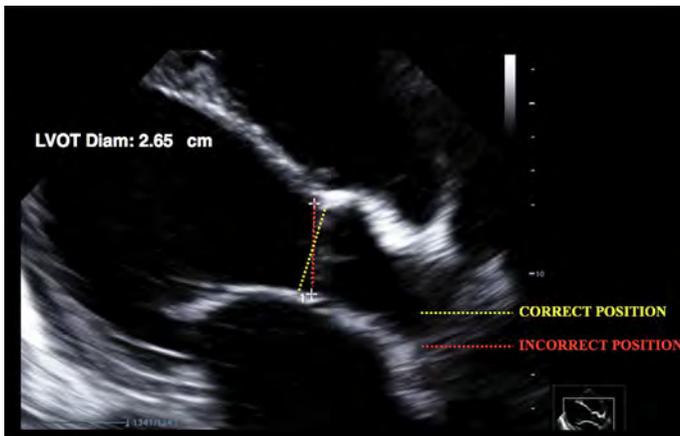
Measurement of the LVOT diameter for estimation of SV. In parasternal long view, the LVOT should be measured placing caliper perpendicular to the direction of flow (yellow dotted line). Note that measurement is being made with image zoomed to increase accuracy.
